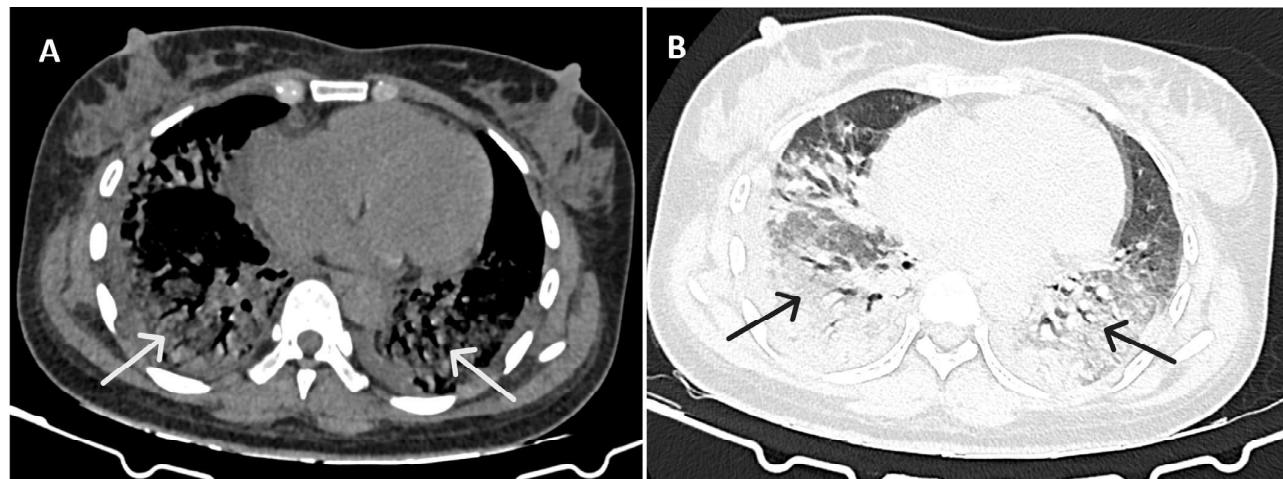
Computerized tomography (CT scan) A: Soft tissue window; B: Lung Window showing extensive consolidation and ground glass opacities and septal thickening predominantly involving lower lobes and posterior segments.
